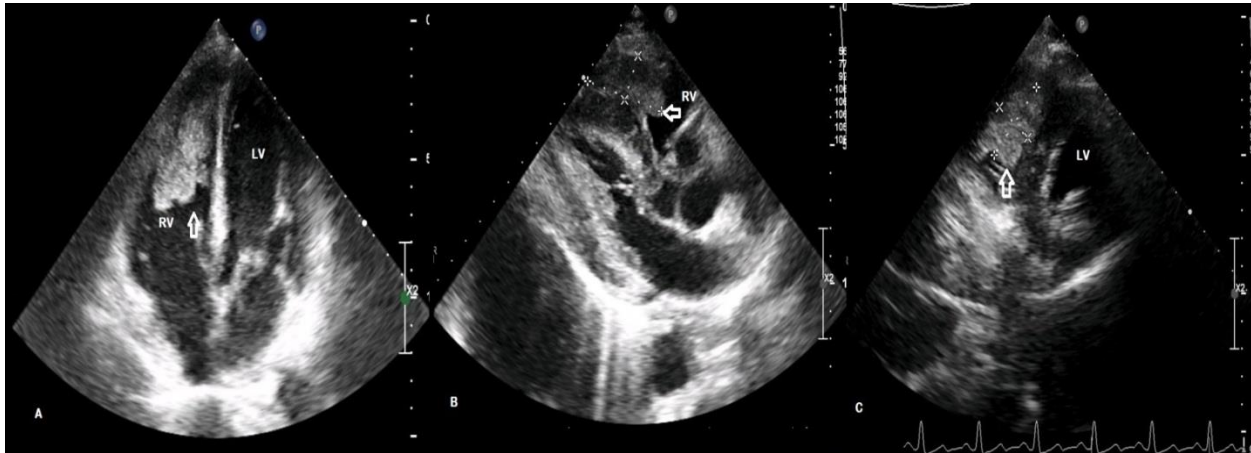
The transthoracic 4-chamber (A) parasternal long axis (B) and short-axis (C) echocardiography views depict a large RV mass (arrow).
